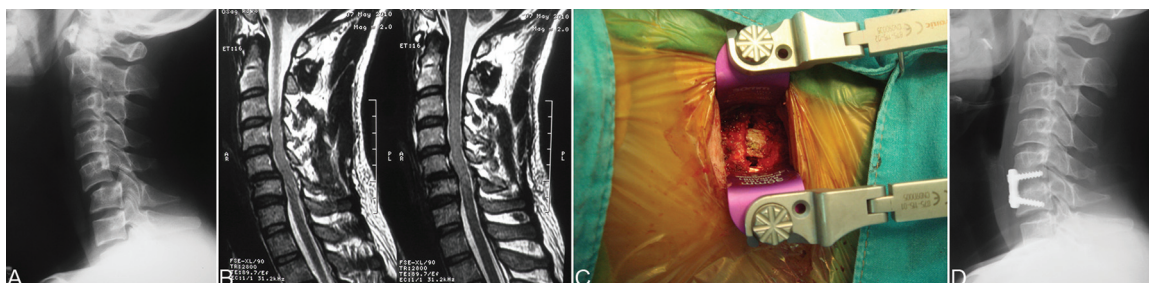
Old/delayed unilateral facet subluxation with myeloradiculopathy (case No. 7). A) Lateral view of the cervical spine showed unilateral C5-C6 facet subluxation with rotational component. B) MRI showed anterior translation C5 over C6 without intervertebral disc herniation. C) Anterior Cervical Discectomy and Fusion was performed. D) Postoperative radiograph showed anatomical reduction of C5-C6 facet joint. Solid bony fusion was achieved 3 months after surgery.
